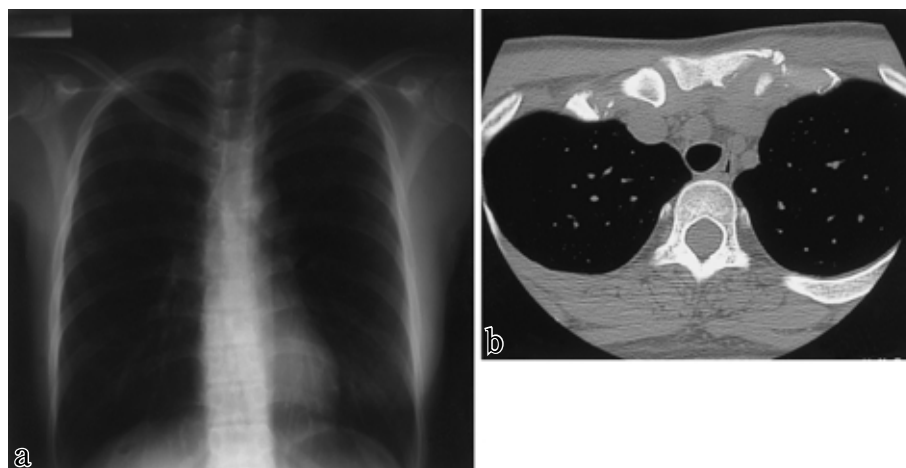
Radiograph and CT at admission to our hospital (September 1998). CT scan demonstrates destructive changes in sternocostal joint which are not observed on plain X-ray examination. Fig. 4-a: Chest radiograph, Fig. 4-b: CT of sternocostal joint
